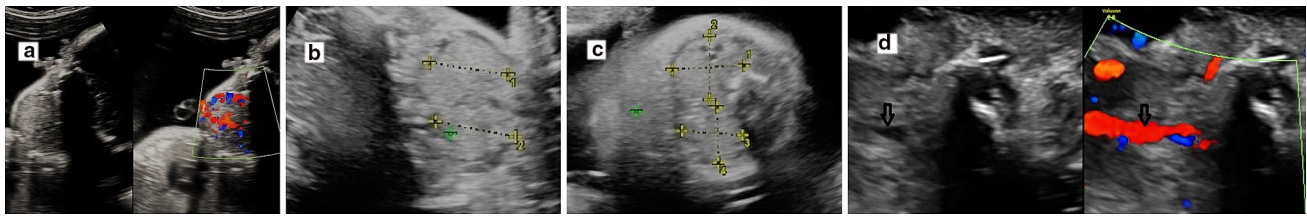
Ultrasound images of hypothyroid goiter of fetus 1. a Sagittal image showing the goiter with demonstration of increased vascularity on color Doppler. b Longitudinal measurements of each lobe of the thyroid gland, and c Antero-posterior and transverse width of each
